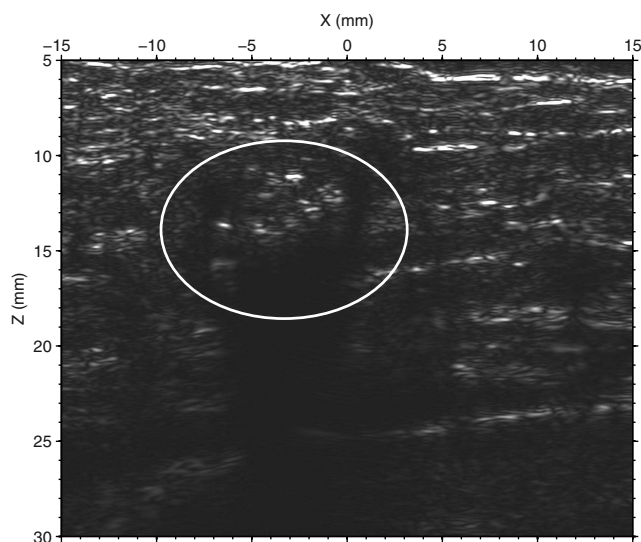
Images of a patient breast obtained with (a) mammography, (b) synthetic-aperture ultrasound, and (c) our PC-MUSIC imaging method. The mammogram of a patient's left breast in (a) indicates that the patient has a 10-mm breast mass with calcifications inside and outside the mass, as shown in the circled region. Our PC-MUSIC imaging produces much more clear images of calcifications inside and outside the breast mass than synthetic-aperture ultrasound does, as shown within the elliptical regions in (b) and (c).
